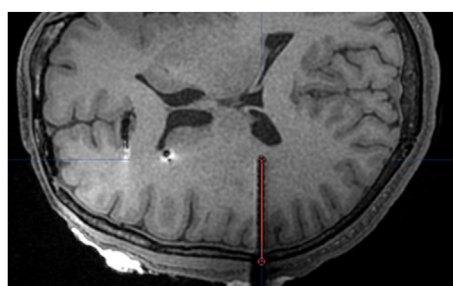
Artifact generated by a parietal electrode on a postoperative magnetic resonance imaging. The generated artifact measures 3.5 mm and the electrode measures 0.8 mm. The real target and entry point were thus estimated by calculating a new trajectory (red line) compared subsequently with the planned trajectory (not shown on this image for clarity).
